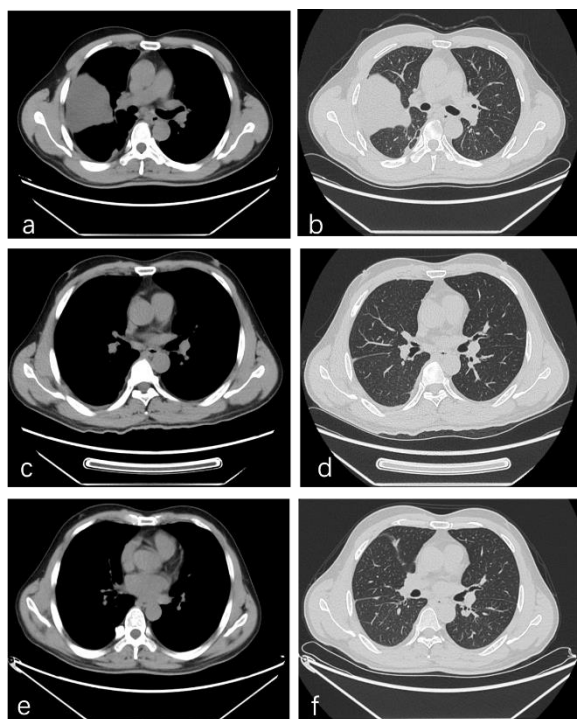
Chest CT on admission showing pleural effusion combined with atelectasis. (a,b); Chest CT on day 17 showing less pleural effusion on the right side (c,d); Chest CT on day 30 days after discharge showing further less pleural effusion on the right side (e,f).
